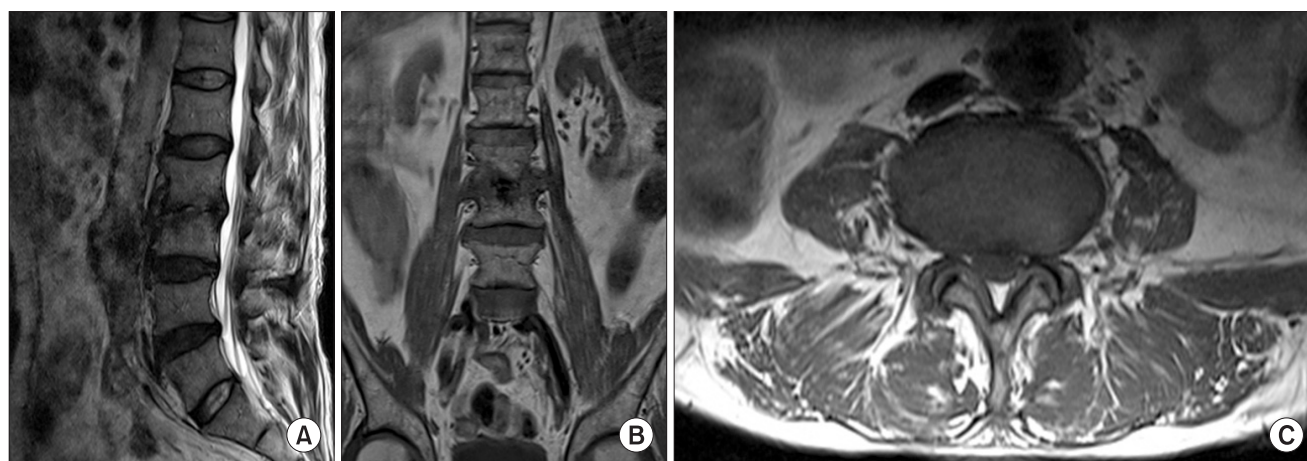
The lumbar spine MRI taken in March 2010. (A) The sagittal plane, T₂-weighted MRI, (B) the coronal plane, T₁-weighted MRI and (C) the transverse plane T₁-weighted MRI.
